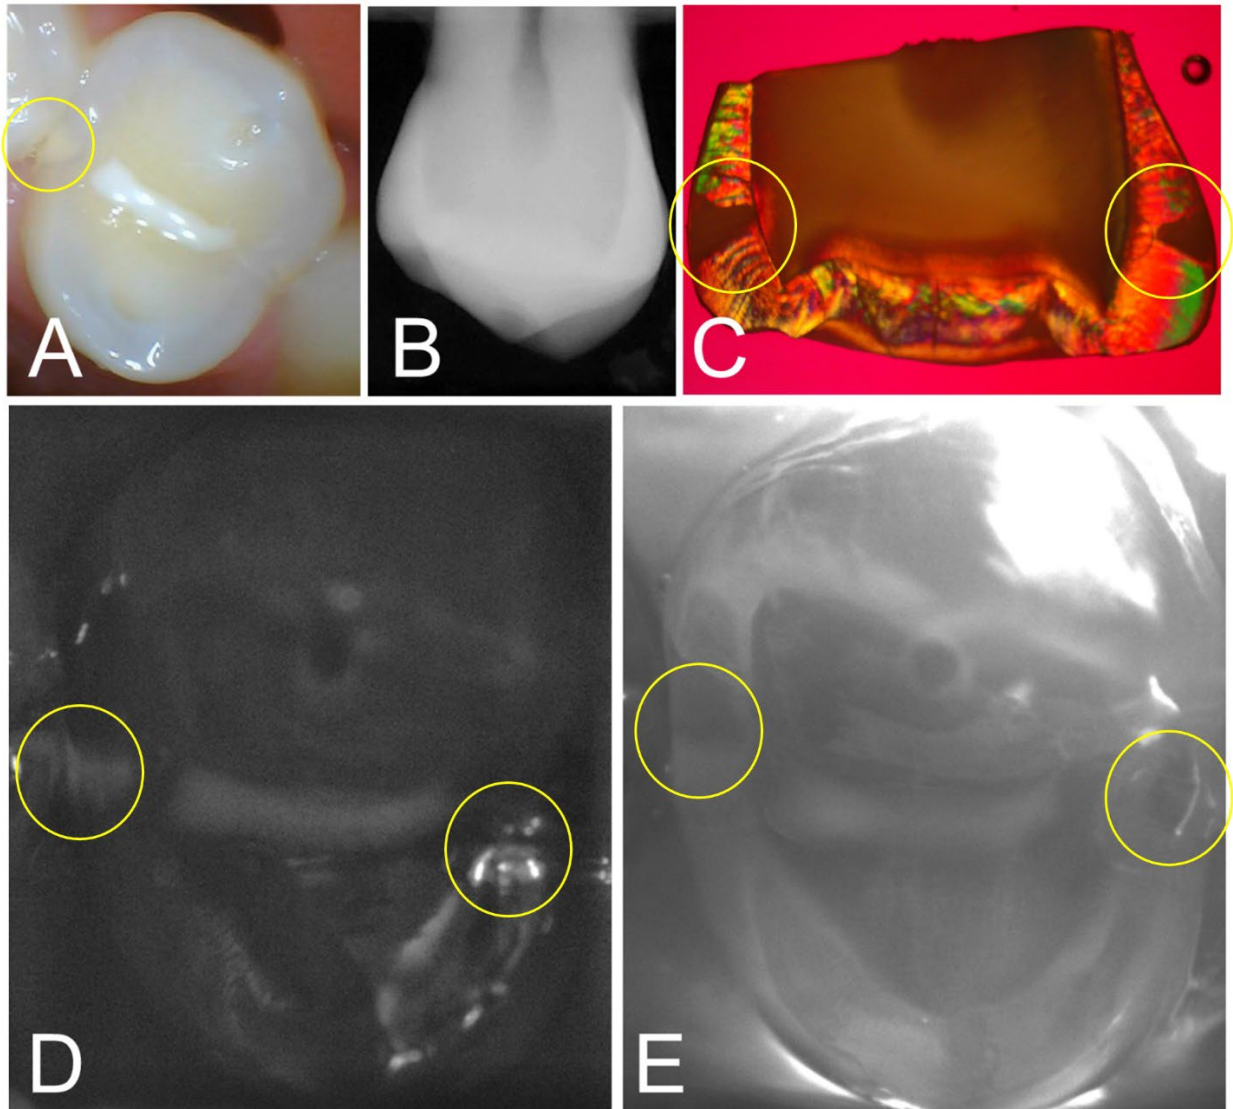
(A) Color image of a bicuspid with a sealant on the central fissure, a lesion is visible at the distal contact, while no lesion is visible on the mesial contact. (B) Radiograph shows no obvious lesions. (C) PLM image of a section cut from the tooth after extraction shows proximal lesions on both surfaces (yellow circles). (D) SWIR reflectance and (E) occlusal transillumination images show lesions on both surfaces.
